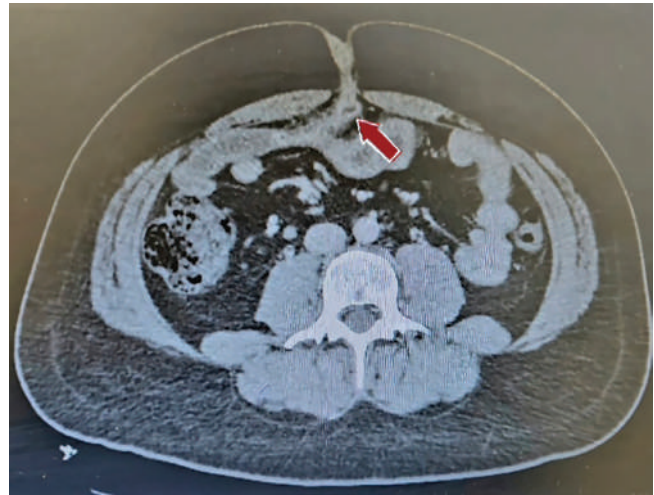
Preoperative abdominal CT. On abdominal CT, a blind-ending tubular structure at the level of the umbilicus with surrounding abscess is observed, consistent with a perforated Meckel's diverticulum.
